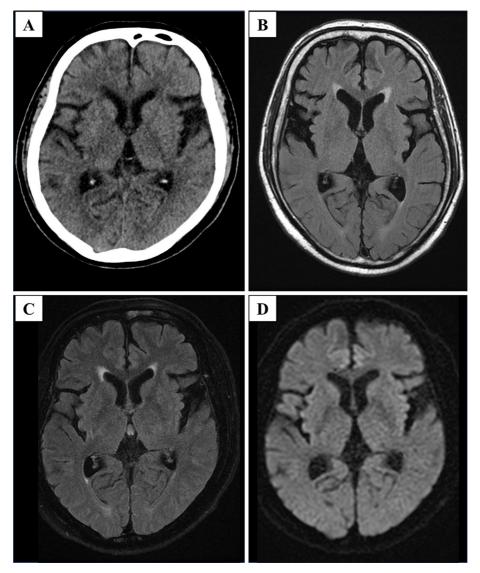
Image findings on admission. A: Head computed tomography (CT). B: T2-weighted magnetic resonance imaging (MRI). C: Fluid-attenuated inversion recovery MRI. D: Diffusion-weighted MRI. Neither head CT nor MRI showed obvious abnormalities.
